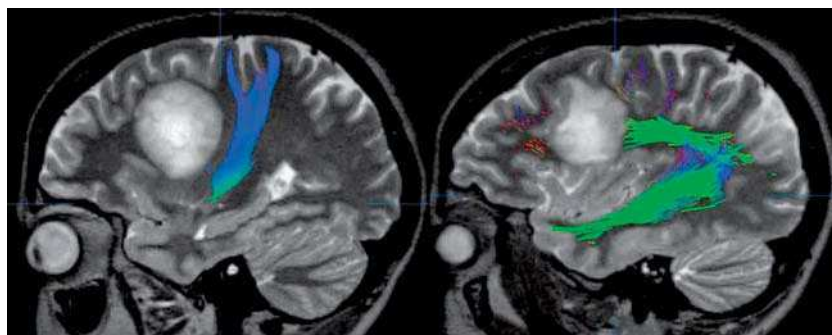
MRI tractography performed on a patient diagnosed with a left frontal pseudo-tumoral demyelinating lesion that produced an interruption of the arcuate fibres (right), but did not affect the corticospinal tract (left). The patient presented conduction aphasia without motor deficit.
